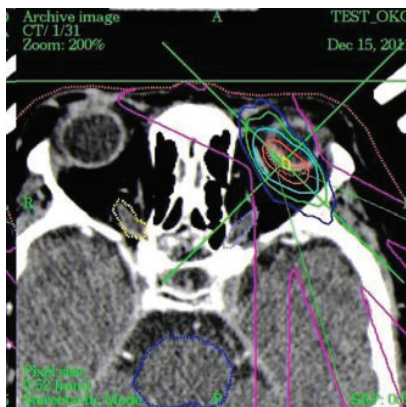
Detail of CT image – dose field in irradiation of tumour in eye by photons, Tdmax – upper limit of dose 37.5 Gy, therapeutic dose TD 35.0 Gy
